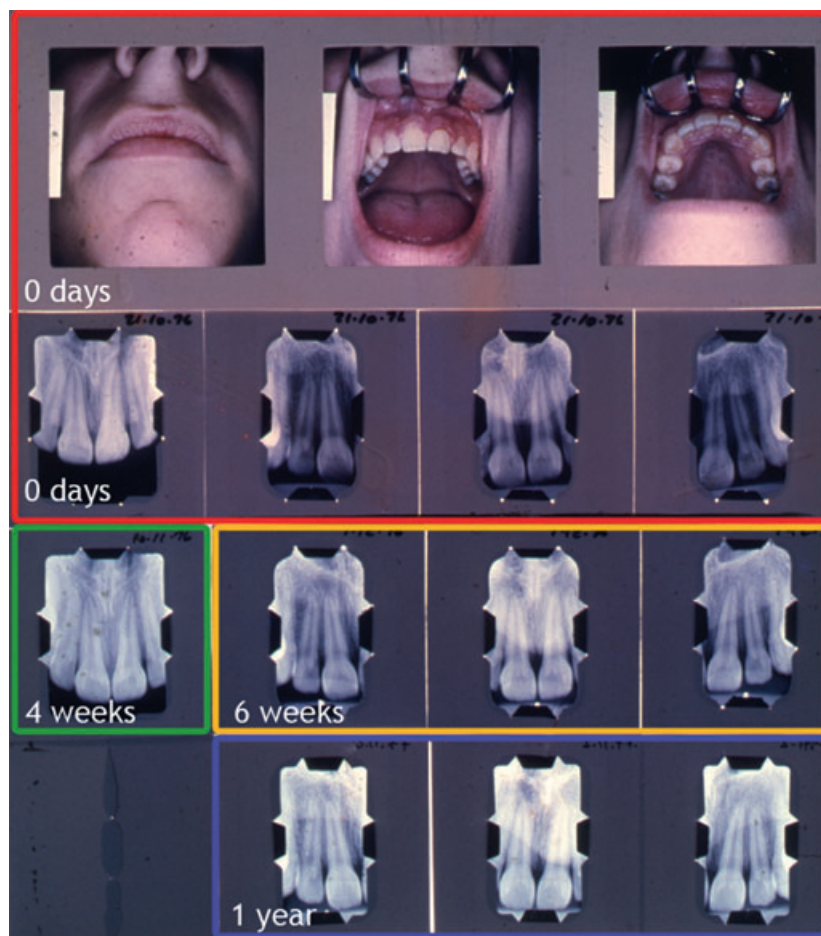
Standardised photographic and radiographic examination of traumatised permanent maxillary incisors. The examination was terminated after 1 year in this patient.
